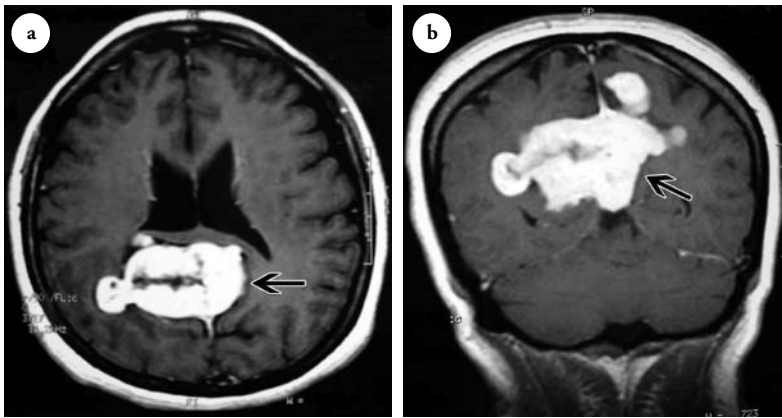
Axial a) and coronal b) postcontrast MR images show a mass lesion that covered the pineal region and extended into the central plane and both parietal sites causing peripheral edema. Homogeneous contrast enhancement is noted.
